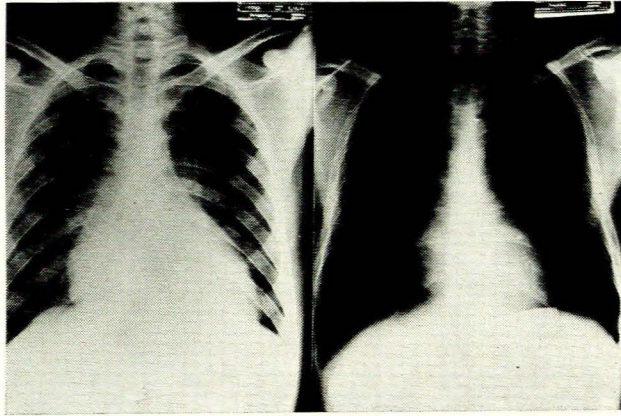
Case 4. Pre- and postoperative X-ray studies.
